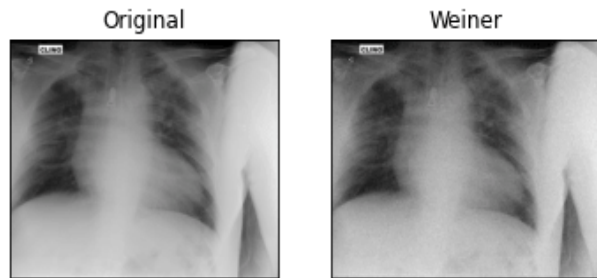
(d). Outputs of second X-Ray image before and after filtering it using Weiner Filter
